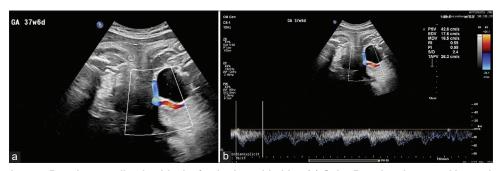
Umbilical artery Doppler sampling beside the fetal urinary bladder. (a) Color Doppler ultrasound image in 37 weeks 6 days fetus in the axial section at the level of bladder showing typical appearance of umbilical artery beside the bladder. In this image, the right uterine artery appears blue, whereas the left umbilical artery is seen in red. (b) Duplex ultrasound demonstrates the umbilical artery wave pattern in the same fetus
